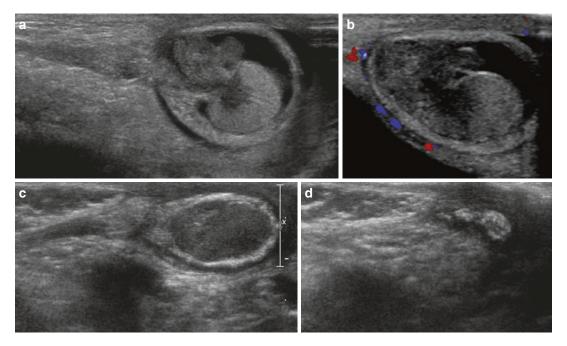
Testicular torsion. Ultrasound images (a and b) in a neonate with an acutely swollen scrotum reveal an enlarged heterogeonous testis. The mediastinum testis is relatively hypoechoic with radiating striations, whilst the surrounding parenchyma is echogenic. Colour Doppler demonstrates peripheral flow but no flow within the parenchyma of the testis. Another case, image (c) shows
